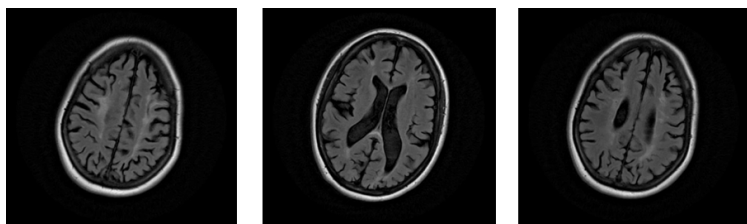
MRI of the brain showed "significant" cortical atrophy along with subcortical white matter changes.
